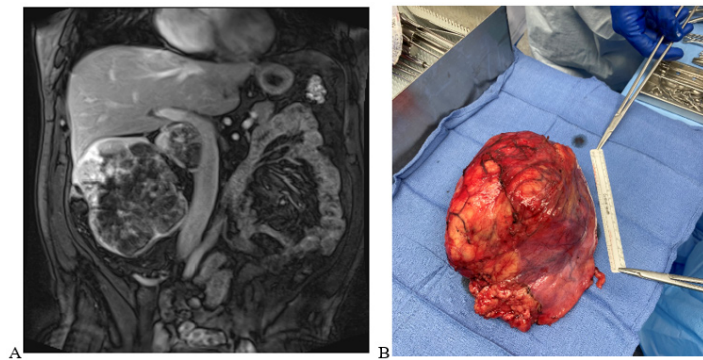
A) Magnetic Resonance imaging (Patient #1) showing a large right mass with a mass pushing the Inferior Vena Cava medially. B) Right renal mass 17 cm long (Patient #1).
